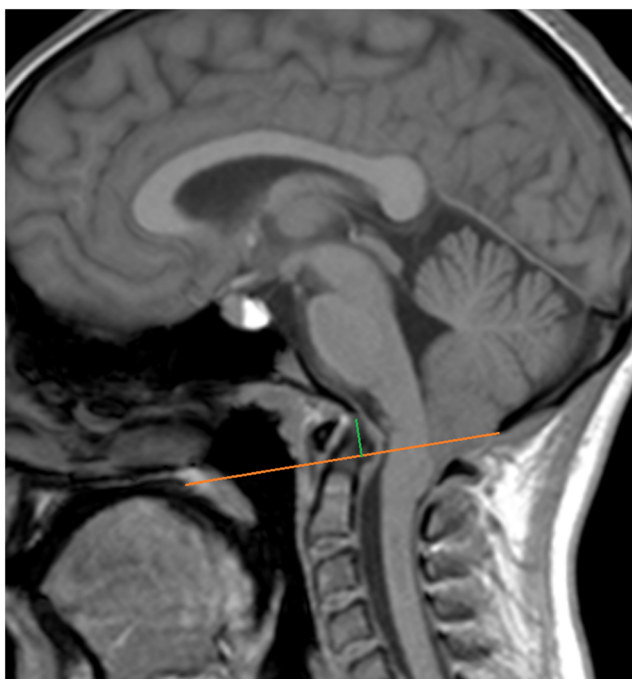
Basilar invagination on a sagittal T1-weighted image. The tip of the odontoid process extends 8 mm above the McGregor line (*brown*). The tip of the odontoid prolapses backward and causes the compression of the cervicomedullary junction. Magnetic resonance imaging (MRI) allows superior visualization of the brainstem and spinal cord compared to computer tomography and should be performed to rule out secondary parenchymal changes
